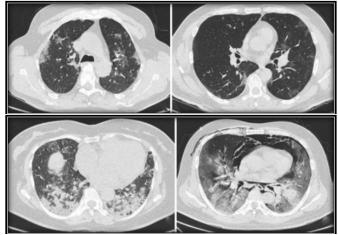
Axial sections of HRCT of the thorax of vaccinated patients (a and b) and non-vaccinated patients (c and d)
